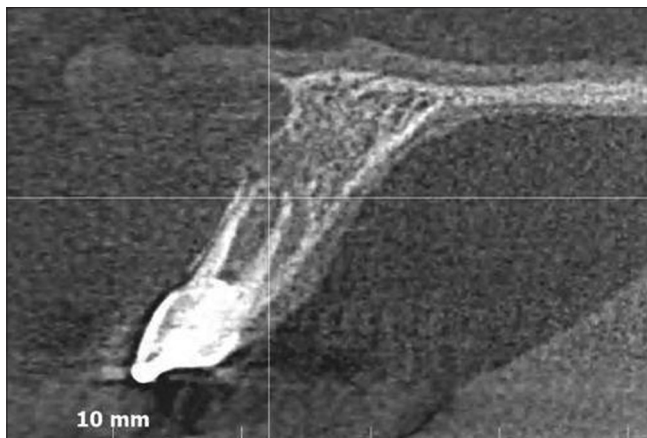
Sagittal section evaluation of cone-beam computed tomography
